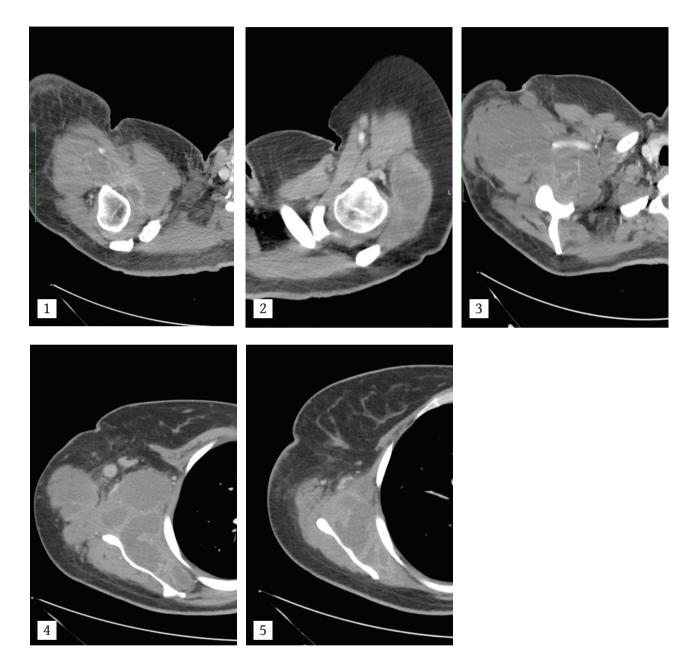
5. Consecutive contrast enhanced CT images
